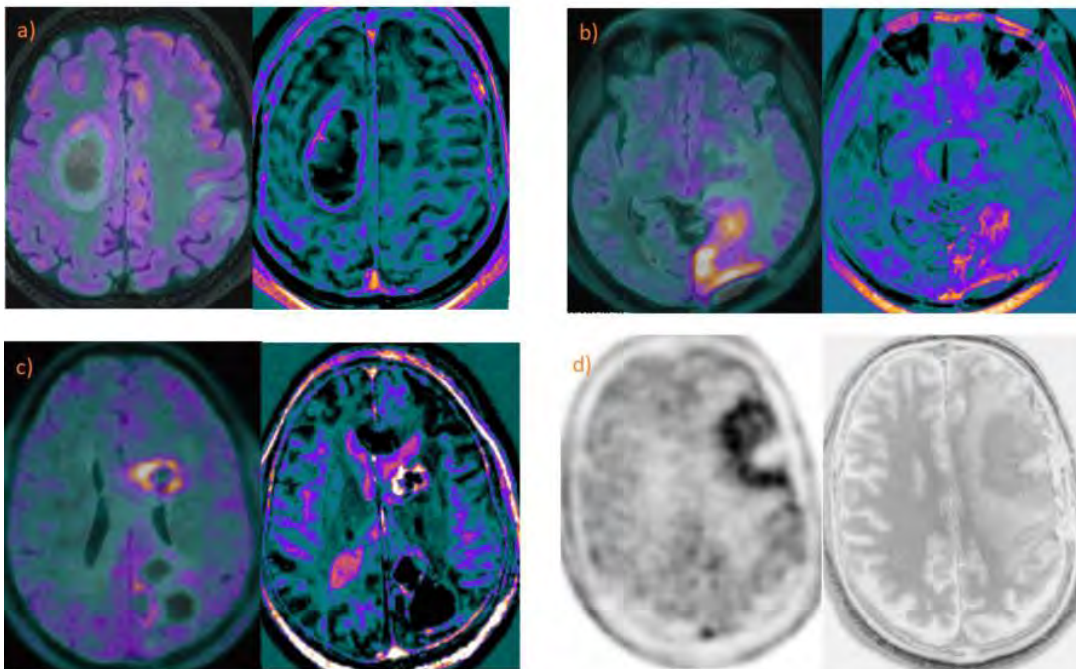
Figure a) shows FDG PET (left) metabolic uptake matched with Subtracted contrast (right) image in case of Adenocarcinoma lung with cerebral metastasis. Figure b) shows F18 DOPA PET (left) metabolic uptake matched with Subtracted contrast (right) image in a case of IDH wild type of Glioblastoma with recurrence in left parieto-occipital lobe. Figure c) shows C11 Methionine PET (left) metabolic uptake matched with Subtracted contrast (right) image in a case of IDH wild type of Glioblastoma with recurrence in pericallosal region. Figure d) shows F18 FET PET AC image (left) metabolic uptake matched with wash out in Delayed contrast (right) image in a case of IDH wild type of Glioblastoma with Residual/ Recurrence in left frontal region.
